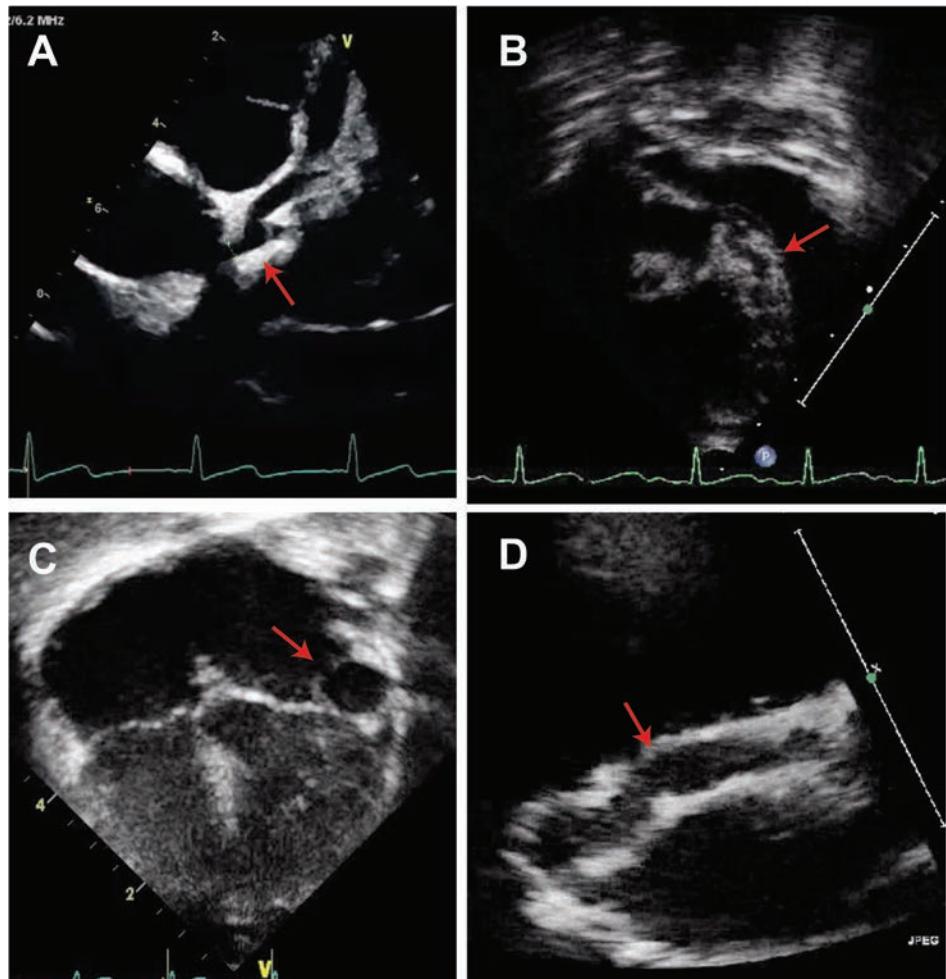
Echocardiographic images of patients with Kawasaki disease showing dilation of the proximal left anterior descending artery (A, arrow), mid left anterior descending artery (B, arrow), circumflex artery (C, arrow), and right coronary artery (D, arrow).
